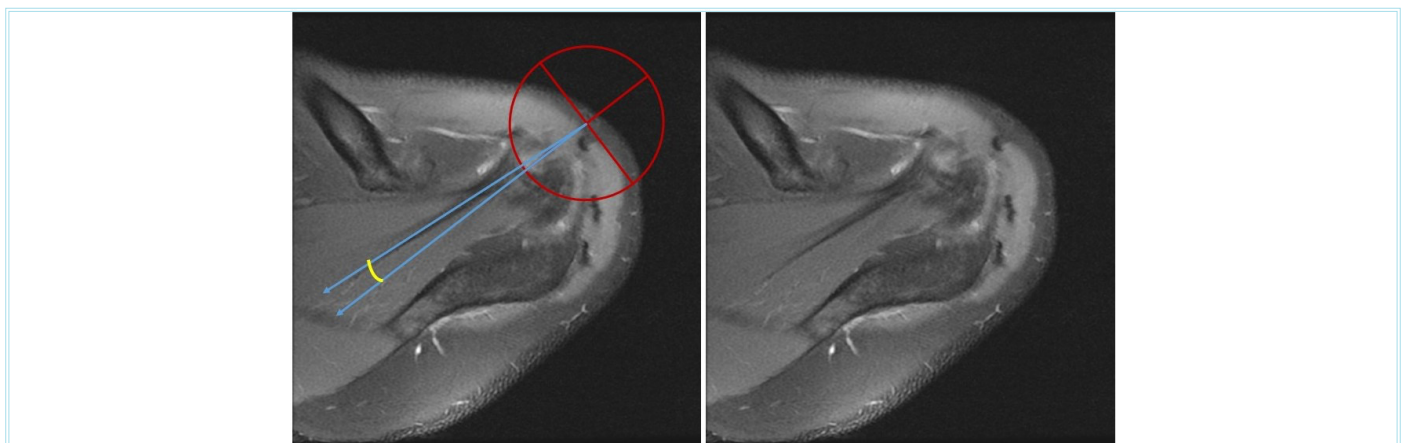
Magnetic resonance imaging axial proton density fat saturation sequence. The red circle demonstrates the humeral head with its transaxial axis. The central tendon angle (yellow arc) was measured between the supraspinatus tendon and the line paralleling the transverse humeral head axis
